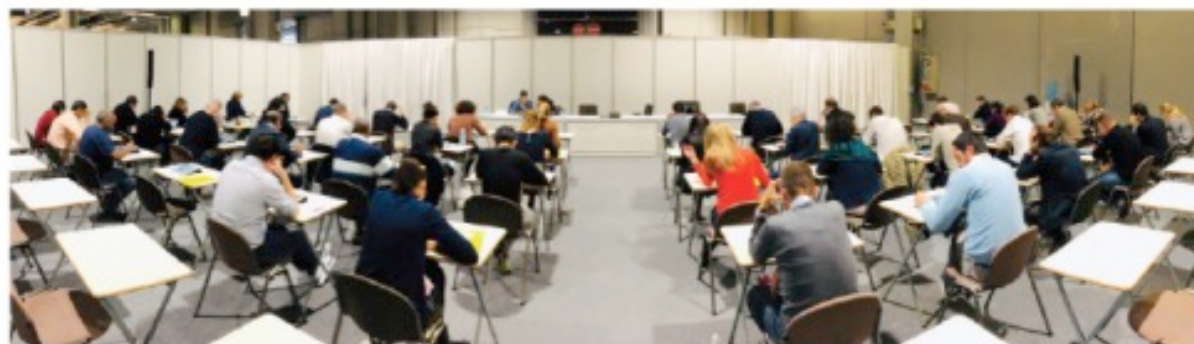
Cardiac computed tomography certification session during Euroecho Imaging Congress 2018 in Milan.
